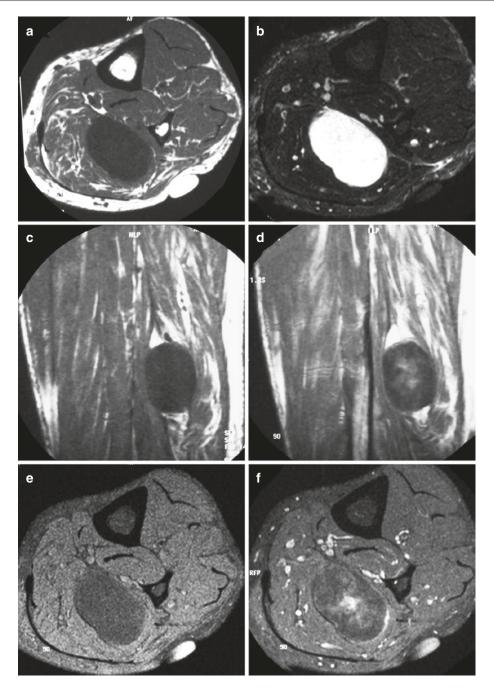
Intramuscular myxoma of the calf. (a) Axial spin-echo T1-weighted MR image. (b) Axial STIR T2-weighted MR image. (c) Sagittal spin-echo T1-weighted MR image. (d) Sagittal spin-echo contrastenhanced T1-weighted MR image. (e) Axial spin-echo T1-weighted MR image with fat suppression. (f) Axial spin-echo T1-weighted MR image with fat suppression after gadolinium contrast injection. Oval-shaped mass within the soleus muscle is observed. The lesion is sharply
